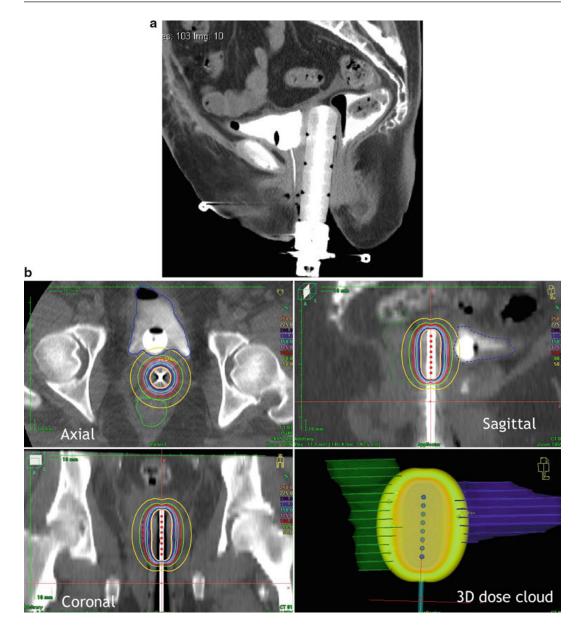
CT-IGBT allows visualization of vaginal apex (a) during treatment planning and delivery (b)
